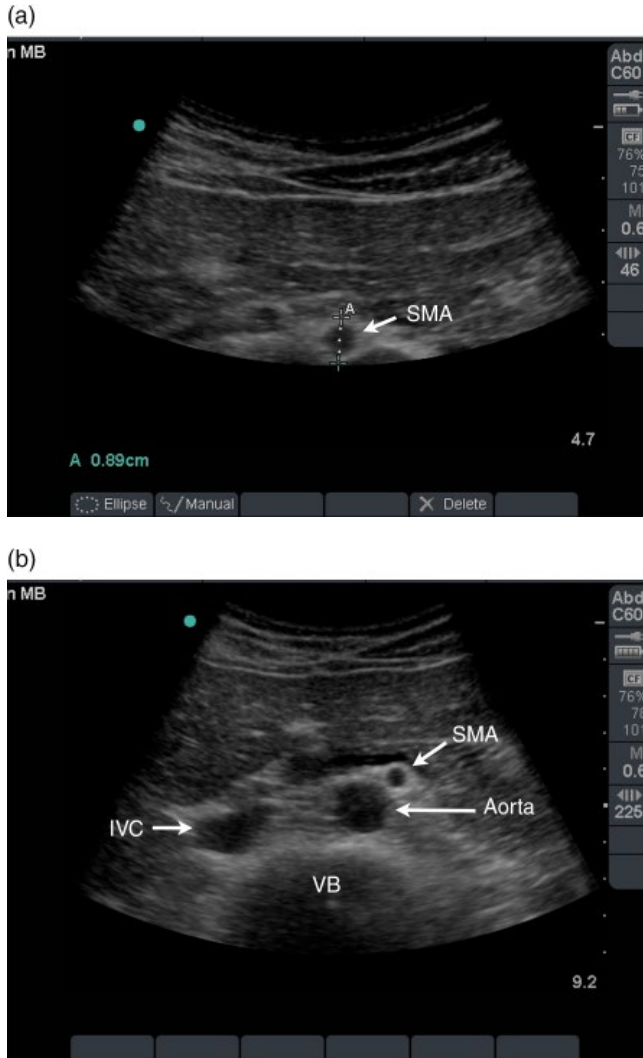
(a) The clinician sonographer has erroneously measured the superior mesenteric artery (SMA) rather than the aorta diameter. (b) The screen depth has been increased and the vertebral body (VB) can clearly be visualised, which enables accurate identification of the aorta, inferior vena cava (IVC) and SMA.
